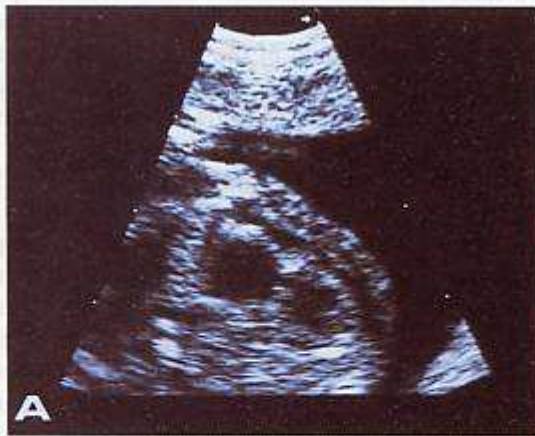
(A) Transvaginal echocardiography of a 15-week gestational age fetus showing just one atrium and a single large ventricle divided by a valve (univentricular heart). (B) Same picture in colour Doppler mode
